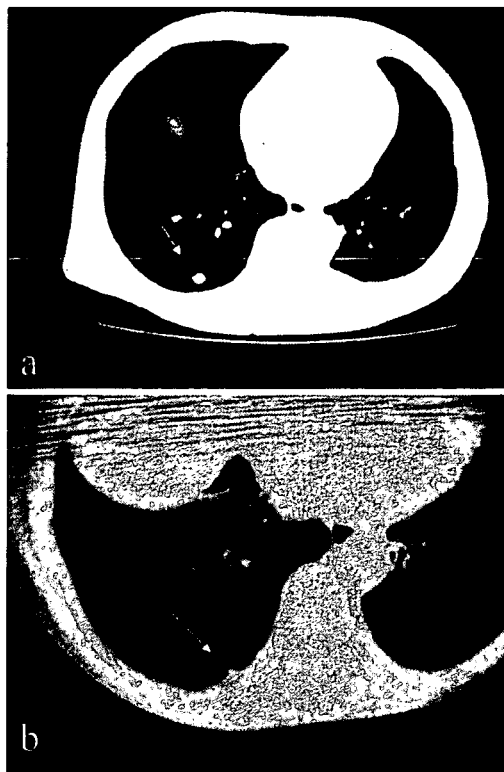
Computed tomography scan of the chest on admission showing two nodules, a 2 cm diameter nodule in the right middle lobe (a) and a 1 cm diameter nodule in the right lower lobe on pleura (b) (arrows).
